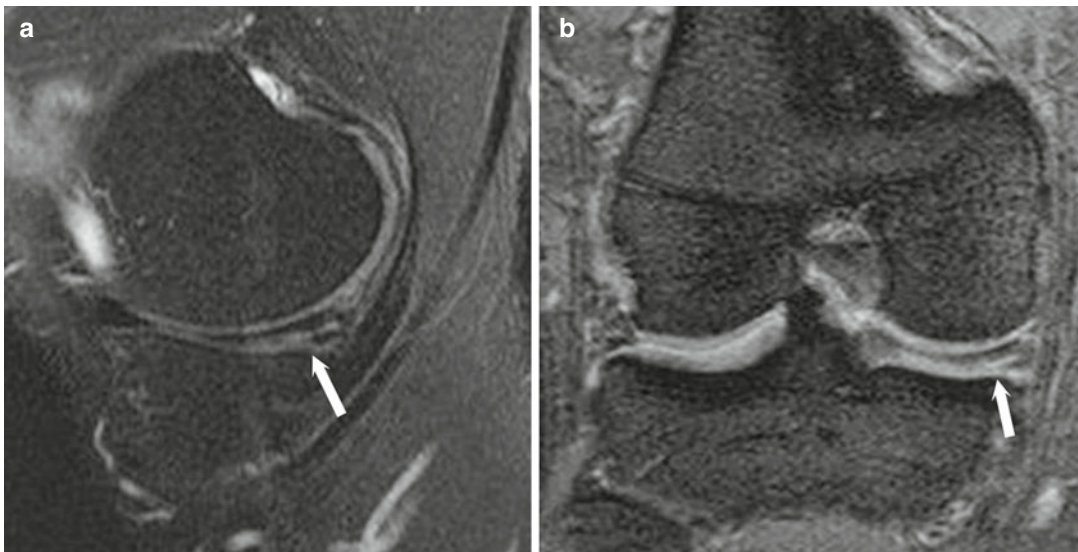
Sagittal (a) and coronal (b) FS T2-weighted image. Medial meniscus tear of the dorsal horn extending lower articular surface (*arrow*) is observed
